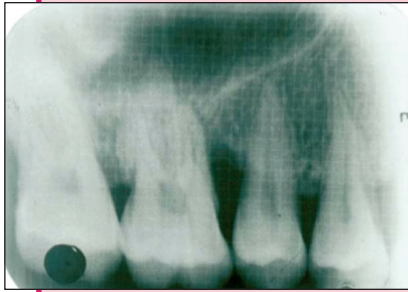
Preoperative radiograph of the test site.
